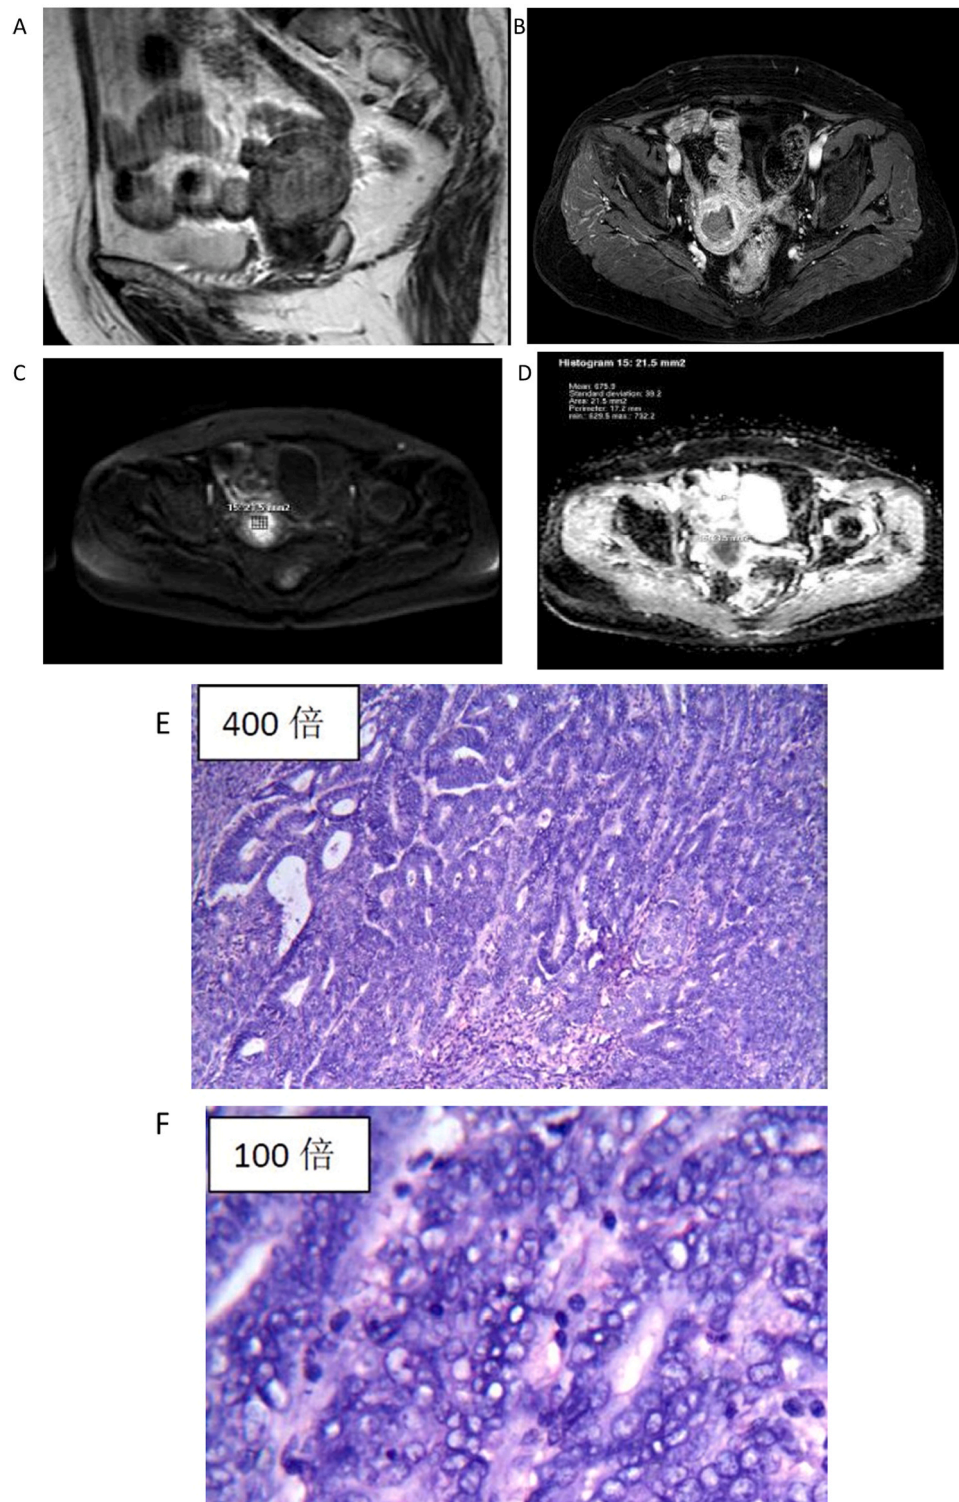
a-b: Sagittal T2WI lesions has a slightly higher signal, shape is irregular, break through the junction infiltrating muscular layer depth is more than 1/2, cross sectional an enhanced visible lesion slightly improved significantly lower than that of myometrium. Fig. 2c-d: Diffusion-weighted imaging (DWI, $b=1000$ s/mm²) showed significantly high signal, while ADC showed significantly low signal, with an average ADC value of 0.759×10^{-3} mm². Fig. 2e-f: Endometrioid adenocarcinoma, deep muscle invasion (> muscle 1/2), grade II (moderately differentiated), lymph node negative.
